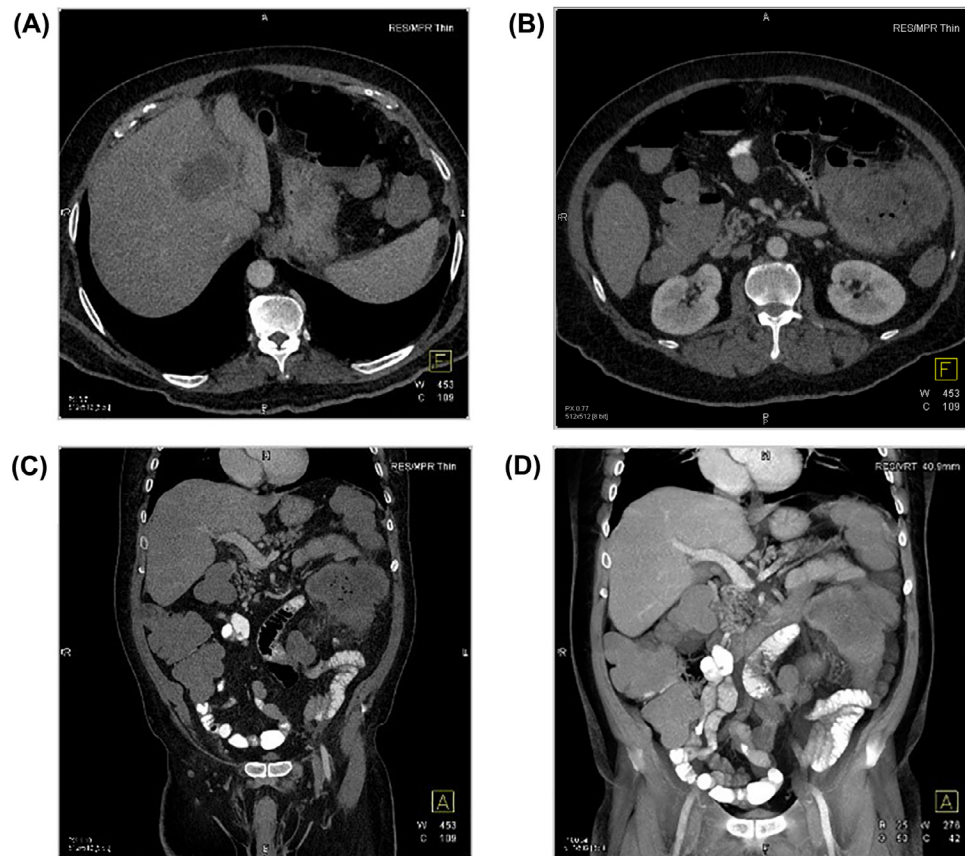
Follow-up CT post treatment without improvement. (A) The liver mass or abscess has increased in size since the prior exam. (B) The necrotic mass involving the bowel has also expanded in size and inflammation has also increased since the prior study. (C and D) Coronal and 3D VRT images define the necrotic mass with air bubbles and inflammation. Differential diagnosis still included inflammatory vs. neoplastic processes. The colon was not obstructed.
